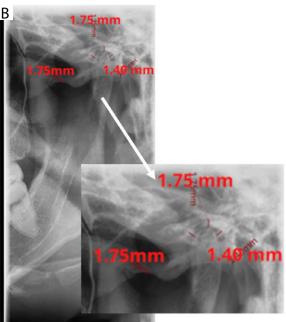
Measurement of joint space of the right and left side of PanTMJ radiograph according to Ikeda and Kawamura's method [9]. A) Right-close. B) Left-close
